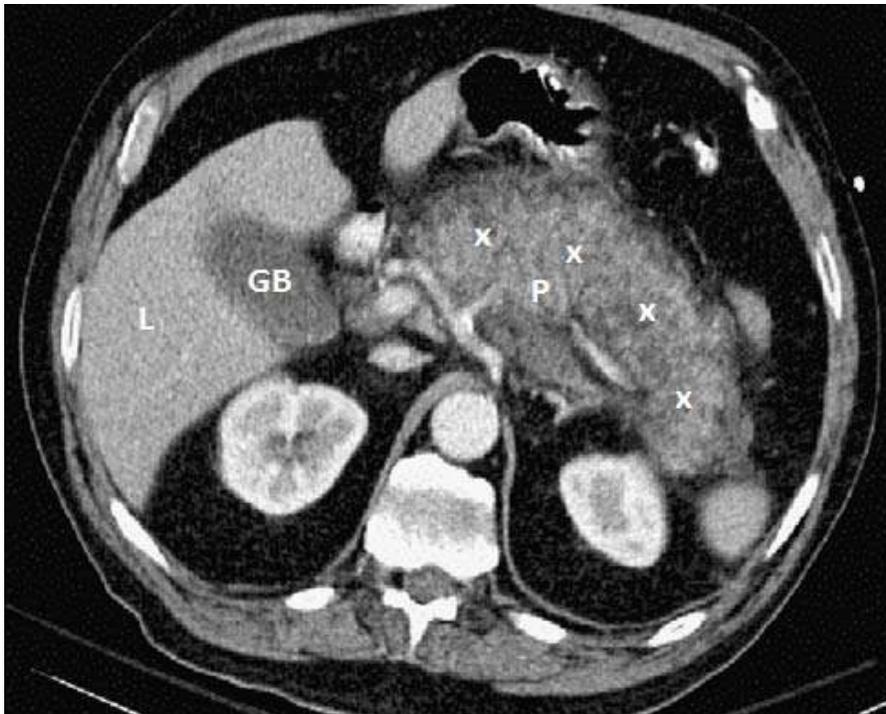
Acute pancreatitis in CT scan
